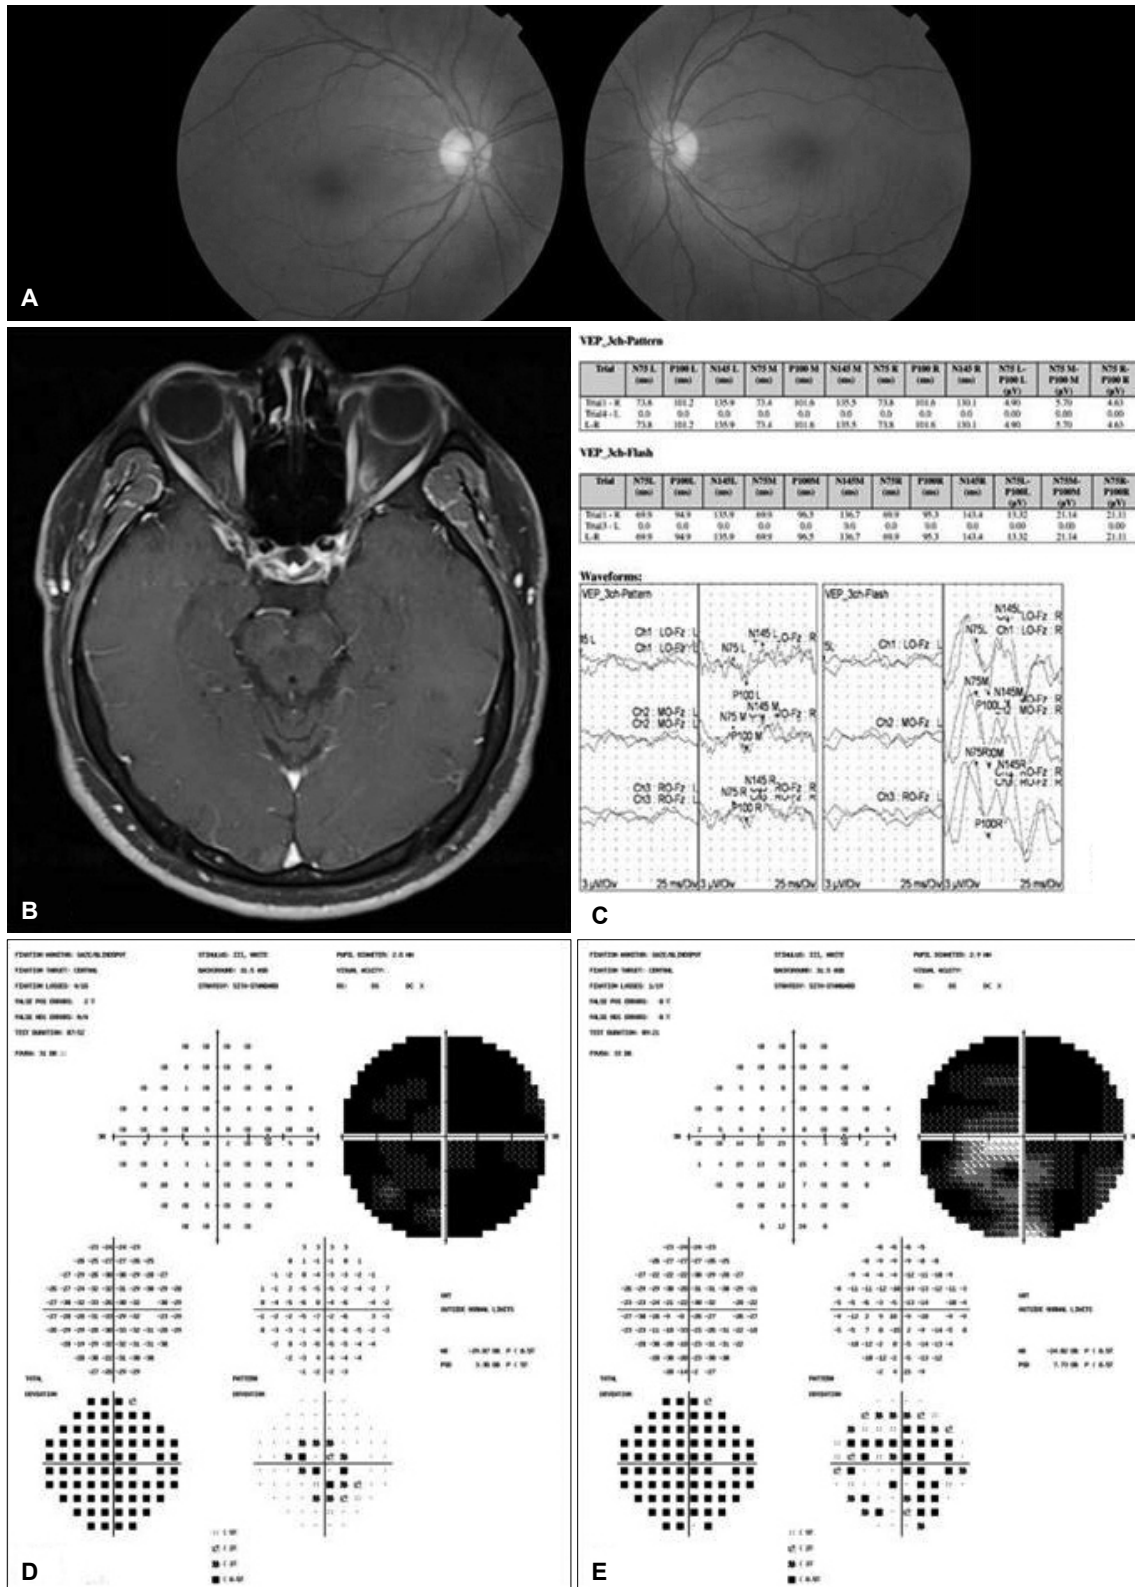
Physical, electrophysiological, and imaging exams of the patient. Ophthalmoscopy images show no morphological alterations (A). T1-weighted post-contrast magnetic resonance imaging demonstrates enhancement of the left optic nerve (B). No visual-evoked potential signal was detected in the left eye (C). Humphrey visual field test shows that the visual field of the left eye was severely constricted before steroids treatment (D), whereas after 3 days of treatment it had mildly improved (E).
